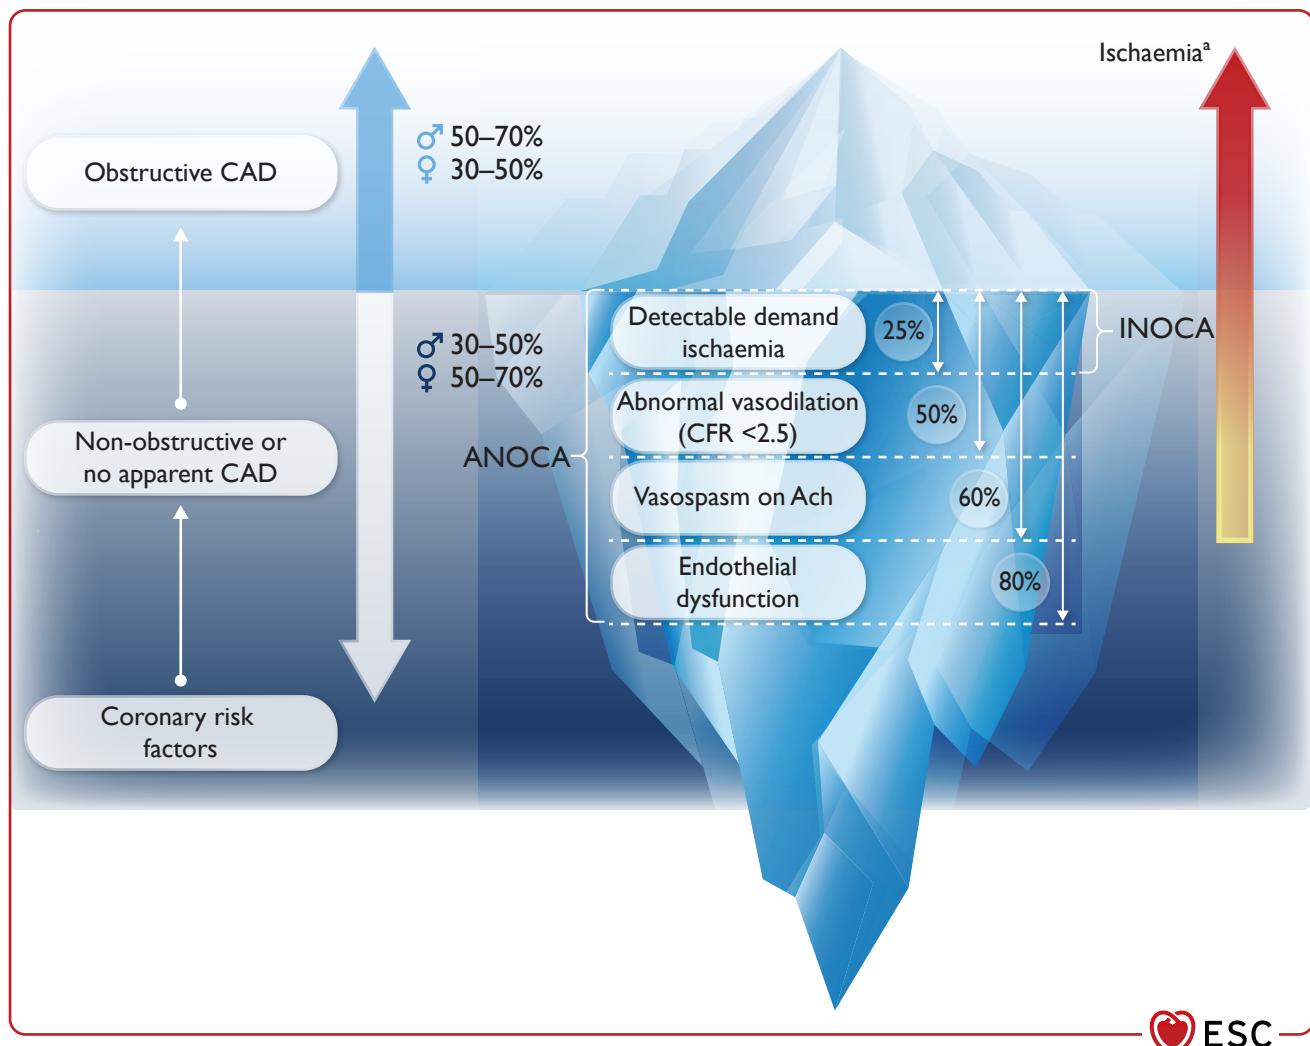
Prevalence of disease characteristics in patients with ANOCA/INOCA referred for invasive coronary functional testing. Ach, acetylcholine; ANOCA, angina with non-obstructive coronary arteries; CFR, coronary flow reserve; i.e., intracoronary; INOCA, ischaemia with non-obstructive coronary arteries. In the ILIAS (Inclusive Invasive Physiological Assessment in Angina Syndromes) registry,⁹²⁷ ANOCA is present in up to 70% of patients referred for invasive coronary angiography and functional testing. Endothelial dysfunction is present in 80% and an acetylcholine test is positive in 60% of these patients. An impaired CFR (≤ 2.5), measured by i.c. Doppler guidewires, is present in 50%, while ischaemia (INOCA) is documented by non-invasive functional testing in only 25% of ANOCA patients. The prevalence of coronary vasospasm can vary in different studies depending on dose of acetylcholine and test protocol.^aPrevalence of ischaemia by non-invasive functional testing increases from non-obstructive to obstructive CAD.
